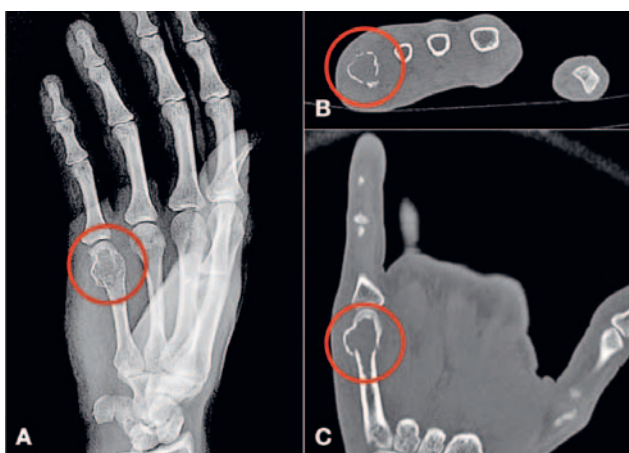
Pre-operative X-ray (A) and CT scans (B, C) of a case with a metacarpal enchondroma before surgical treatment.
